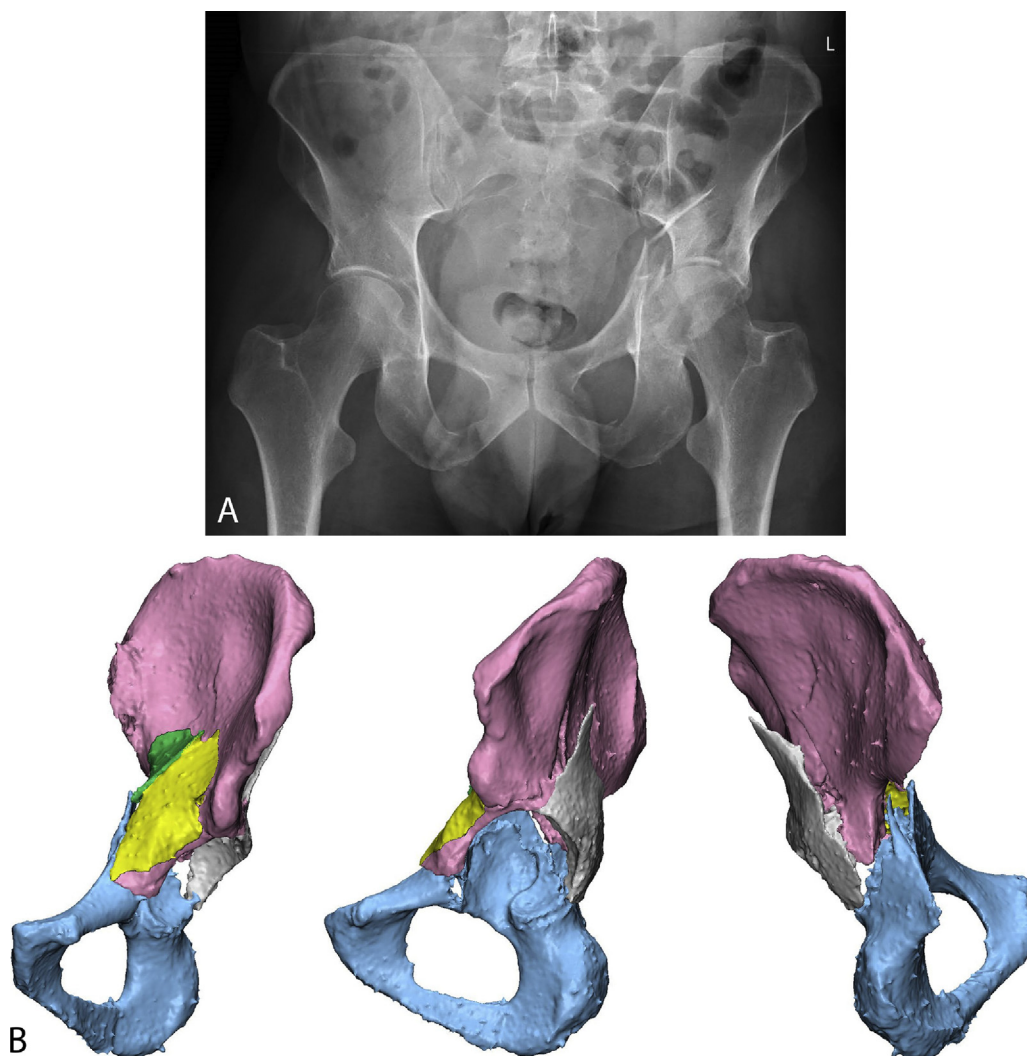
Pelvic radiograph AP view (A) and 3D reconstruction (B) of a left acetabular fracture (type AO/OTA 62-C3.3). The CT scan showed a mild protrusion of the femoral head due to a displaced acetabular fracture involving the iliac wing, extending to the acetabular roof, reaching up to the quadrilateral plate, and involving both the anterior and posterior columns.
